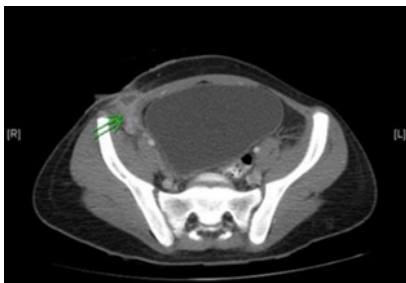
CT scan two weeks later showing residual subcutaneous fluid collection.
